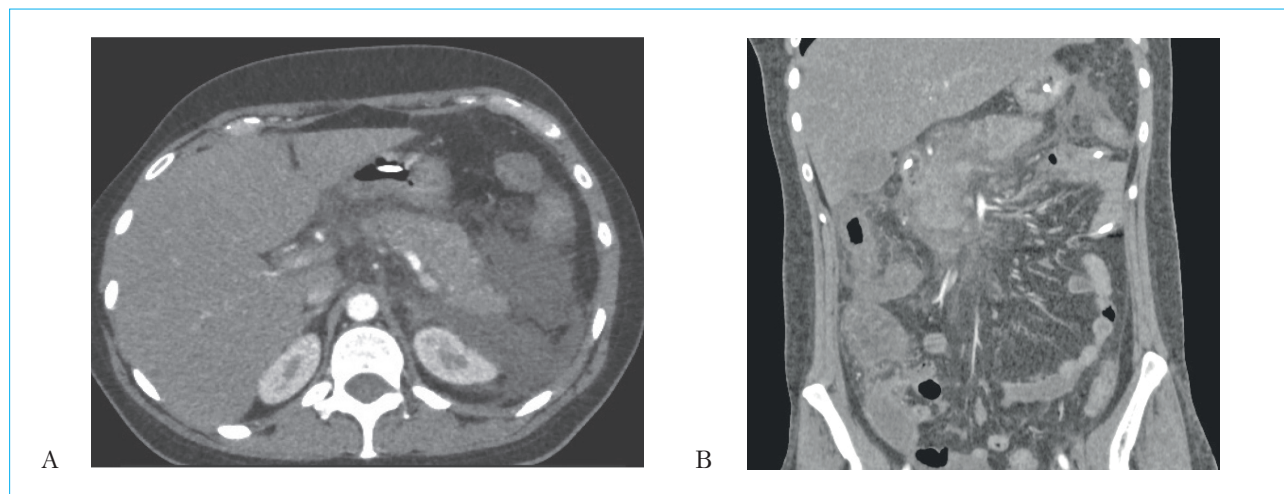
CT scan of the abdominal organs at admission to the hospital. Signs of pancreatitis in the form of an increase in the size of the pancreas, the contours are fuzzy, areas of hypoperfusion are determined in the structure of the pancreas — zones of pancreatic necrosis, the main pancreatic duct is not expanded. In the parapancreatic fiber with the spread into the lateral channels and interstitial, effusion is determined in a significant amount
